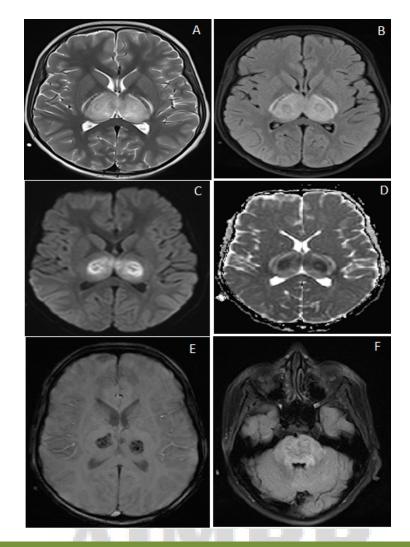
MRI BRAIN - T2WI (A) and Flair (B) Images ShowHyperintense lesions in bilateral thalamus which shows intense diffusion restriction in the center. DW1 (C) and ADC (D) with hemorrhage in the center of thalamic lesions on SW1 images (E). Flair Images (F) showing Hyperintensity in Pon s.
